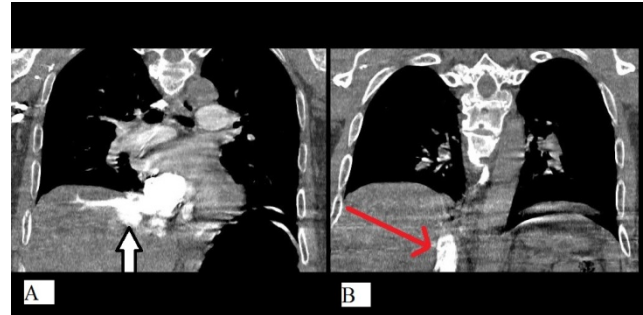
Coronal views of pulmonary CT angiography (with PTE protocol)
